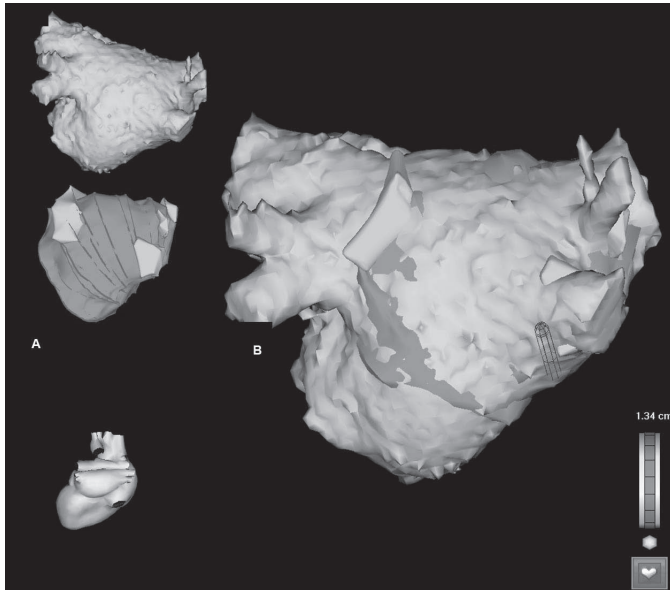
After 3D mapping with ICE, the 3D map and multi-slice computed tomography (MSCT) image are displayed next to each other (A). Then a manual registration process is performed. This results in the integration of the 3D map and the MSCT image in order to anatomically guide the ablation procedure (B).
